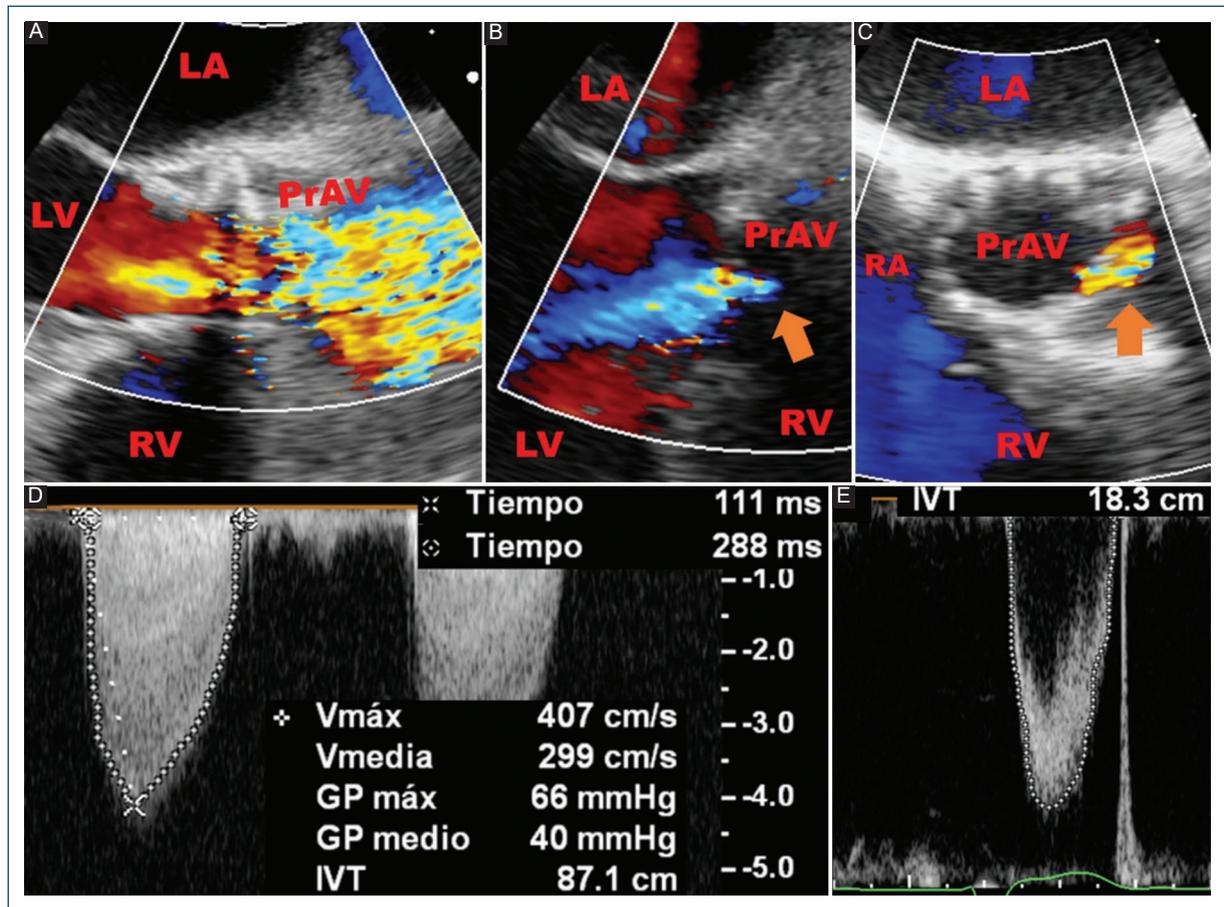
Transesophageal echocardiography: Prosthetic aortic valve with thickened transcatheter aortic valve replacement leaflets with abnormal mobility, valvular stenosis, and new occurrence of moderate regurgitation (orange arrow). Parameters: AT 111 ms, LVET 288 ms. AT/LVET ratio 0.38, peak velocity 4.07 m/s, peak gradient 66 mmHg, mean gradient 40 mmHg, VTI_{LVOT} 18.3 cm, VTI_{PrAV} 87.1 cm, DVI 0.2 (baseline 0.58), EOA 0.6 cm² (baseline 1.32 cm²). A: 2D image with color Doppler, mid-esophageal view at 135° (long axis). B: 2D image with color Doppler, mid-esophageal view at 135° (long axis). C: 2D image with color Doppler, mid-esophageal view at 45°. D: continuous-wave Doppler across prosthetic aortic valve. E: pulse-wave Doppler in the left ventricle outflow tract. AT: acceleration time; EOA: effective orifice area; DVI: Doppler velocity index; LA: left atrium; LV: left ventricle; LVET: left ventricular ejection time; RA: right atrium; RV: right ventricle; PrAV: prosthetic aortic valve; VTI_{LVOT} : left ventricular outflow tract velocity-time integral; VTI_{PrAV} : prosthetic aortic valve velocity-time integral.
